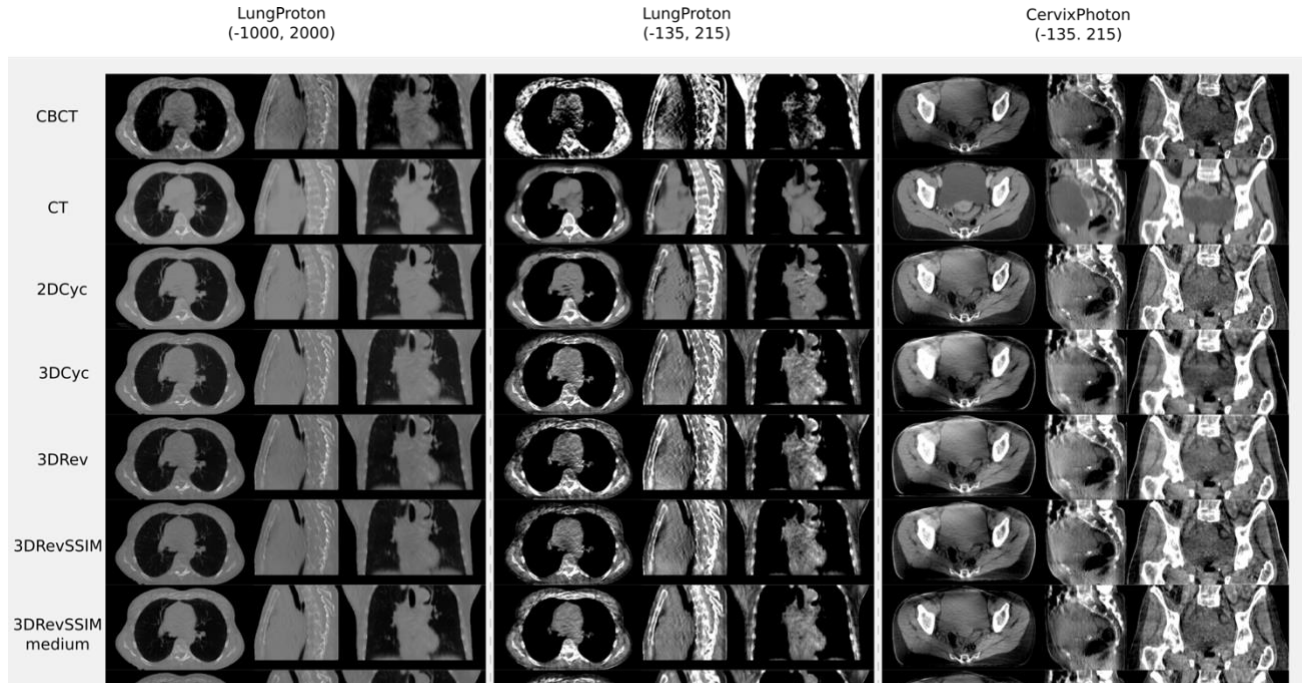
Qualitative results of translation for different models, shown on a patient chosen randomly from the test set, for both the LungProton and CervixPhoton datasets. The images are categorized based on the dataset and HU viewing. For each of these categories, the input CBCT, target CT, and translations from different models are shown (labeled on the left).
